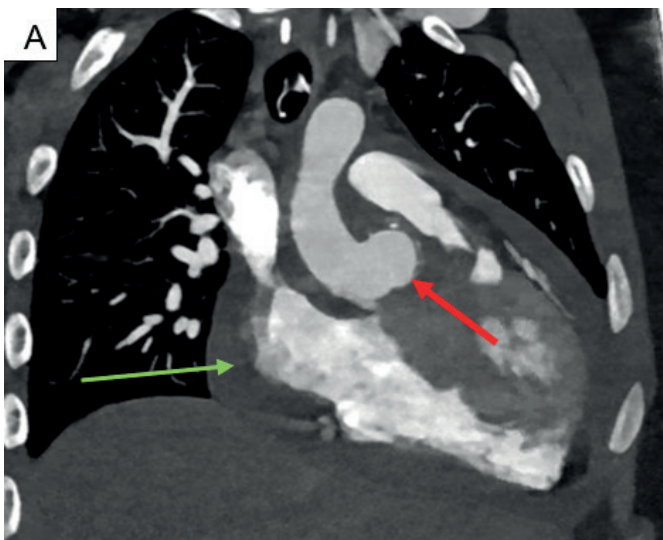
are modified coronal and axial reconstructions from a gated CT Angiogram. These demonstrate a ruptured mycotic aortic root pseudoaneurysm in a patient with aortic valve endocarditis. The pseudoaneurysm arises from the right aortic sinus and measures 22 mm x 17 mm x 22 mm (red arrows). There is a sliver of contrast lateral to the aortic root (yellow arrow) alongside large volume hemopericardium (green arrows) in keeping with an active bleed.
